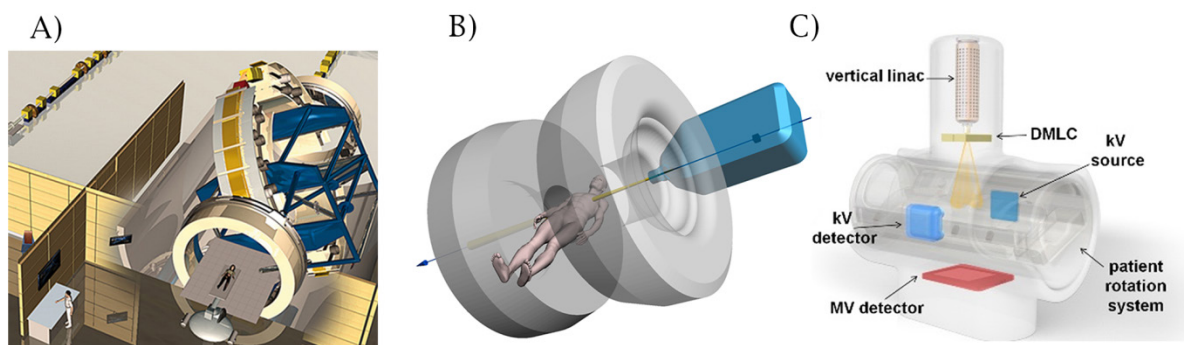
There are a number of treatment modalities which could derive considerable benefit from patient rotation. A) Heavy ion and proton therapy utilise much larger and heavier gantries than conventional therapy. Shown here is the rotating carbon ion gantry at the Heidelberg Ion Therapy Centre. B) Integrated MRI-Linac systems result in very complicated gantry mechanics. (Adapted with permission from Constantin et al. [11]) C) Patient rotation can help to address a devastating global short fall of linear accelerators. Show here is the Nano-X device. (Adapted with permission from Eslick et. al. [4])
